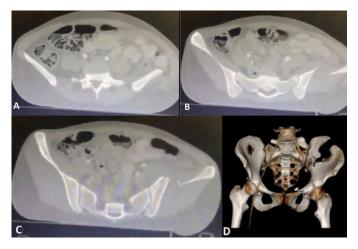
CT images taken in the emergency department (a-c) Pelvic CT horizontal images (d) Pelvic CT-3D image.
